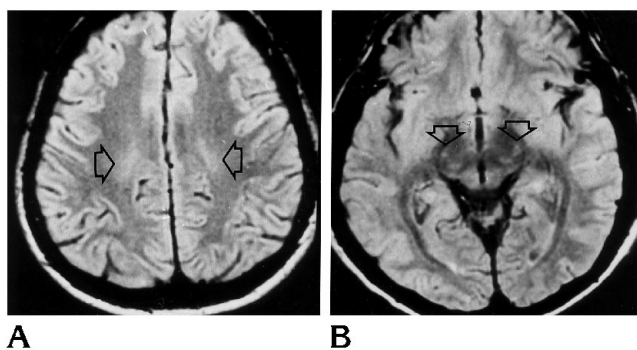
Case 1 (primary lateral sclerosis). Axial proton density-weighted spin-echo MR images (1800/40/2) show symmetric hyperintensity (arrows) in the centrum semiovale (A) and in the cerebral peduncle (B).
